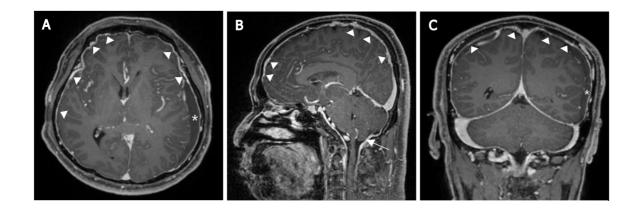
Magnetic resonance T1-weighted imaging. A: Axial scanning showing a large amount of multistage subdural hematoma (SDH) in the left cerebral convexity and dural enhancement in both cerebral convexities (especially prominent right cerebral convexities); B: Sagittal scanning showing dural enhancement and mild sagging appearance of the brain; C: Coronal scanning showing a large amount of multistage SDH in the left cerebral convexity and dural enhancement in both cerebral convexities. Asterisk: SDH; Arrowhead: Dural enhancement; White arrow: Sagging appearance of the brain.
